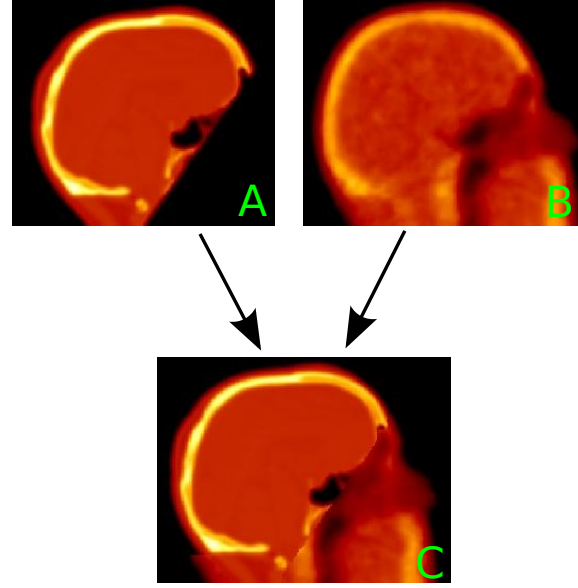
Scheme showing the derivation from a partial CT (A) to a hybrid CT (C) by completing the partial CT with template AC information (B).
